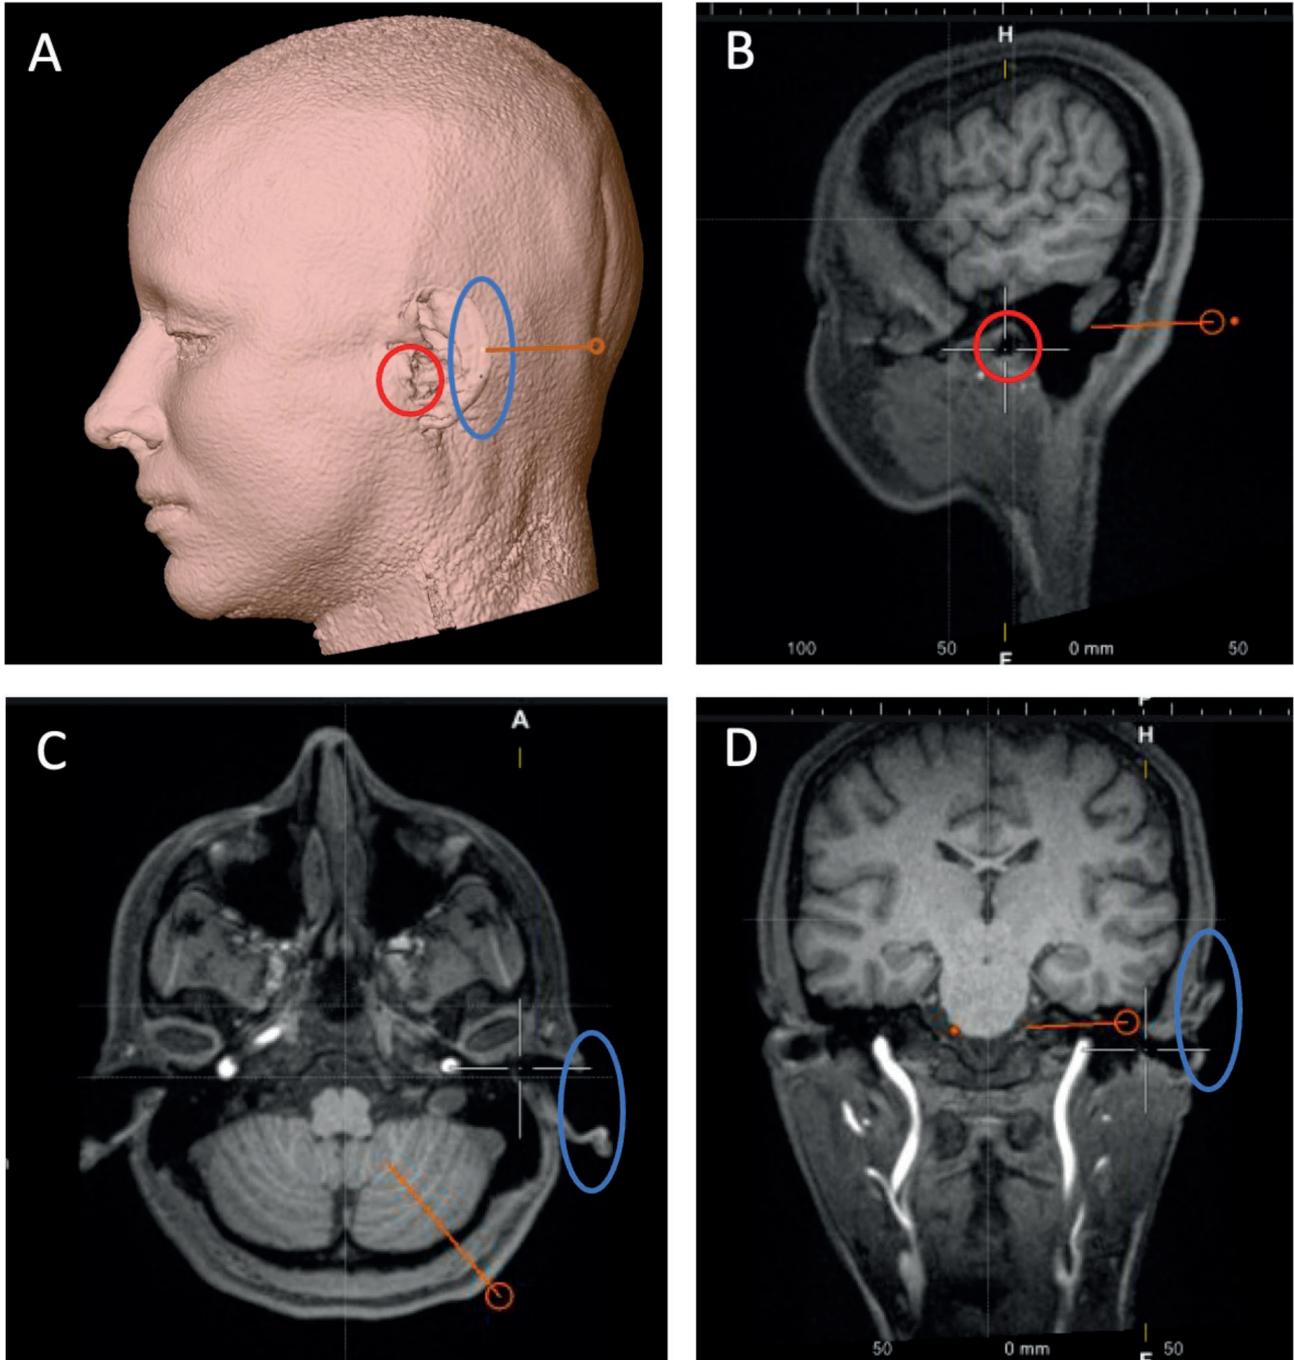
A) Trajectory (orange) and landmarks (ear canal (red) and ear lobe (blue)) on 3D model. B) sagittal, C axial, D) coronal slides on MRI images on which the location of the entry point can be defined in relation to extra-cerebral landmarks.
